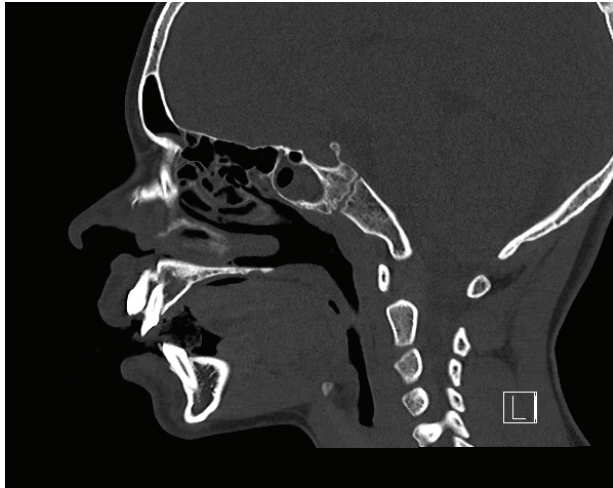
Sagittal CBCT views showing the position of the maxillary central incisors
